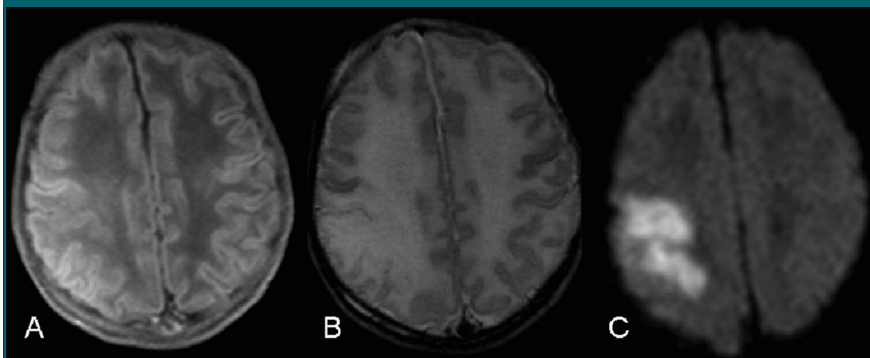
MR images at day 3 in an infant with a good motor outcome at the age of 2 years and an infarct in the right parietal region. *A*, High signal intensity on T1-weighted MR image. *B*, An abnormal cortical ribbon on T2-weighted MR image. *C*, High signal intensity on DW image ($b = 1000 \text{ sec/mm}^2$).
